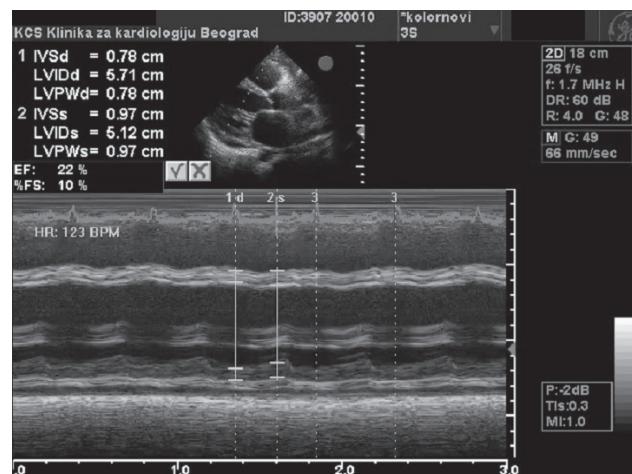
The echocardiographic finding of the left ventricle in M-mode (long parasternal view) at admission to our hospital
